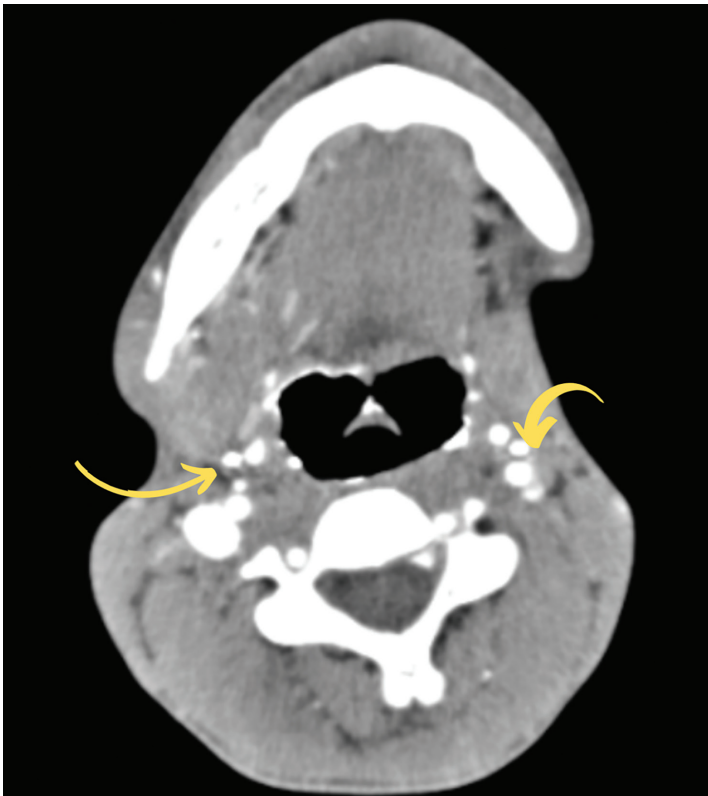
CT axial section fistulogram images in bone window showing bilateral external openings (arrows).
